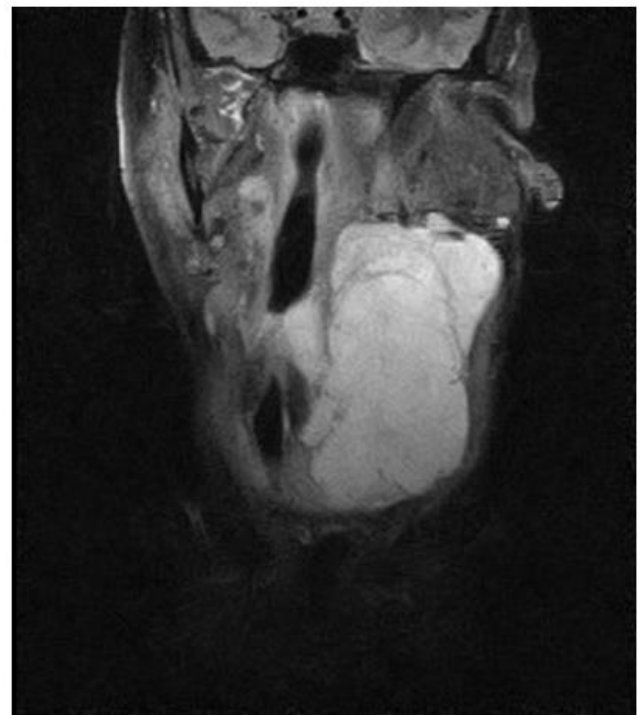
STIR MRI demonstrating left neck mass with compressive symptoms
